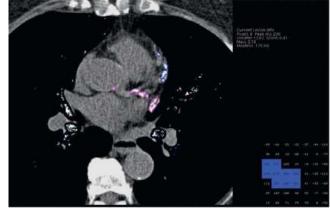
Example of significant coronary artery calcium from a multidetector CT scanner
